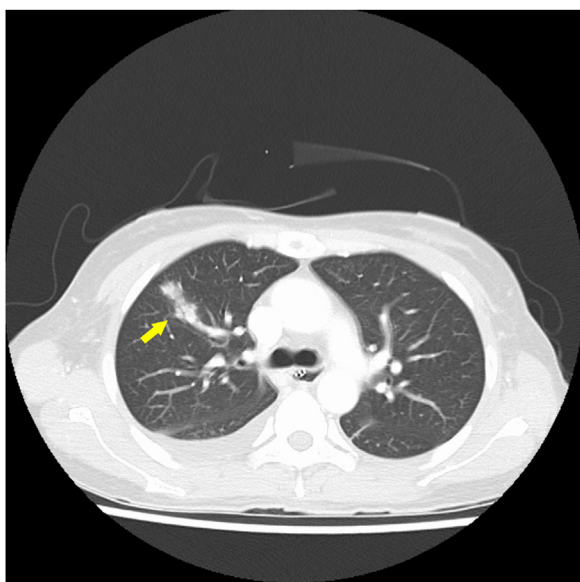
Contrast-enhanced computed tomography showed consolidation in the S3 region of the upper lobe in the right lung (arrow).
